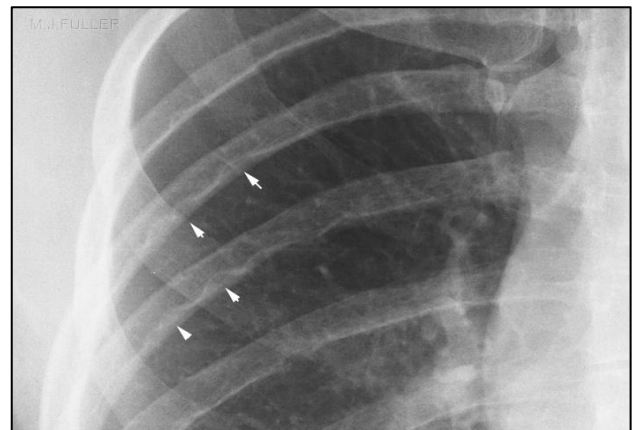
Chest X-ray suggestive of notching of inferior margins of the ribs.
